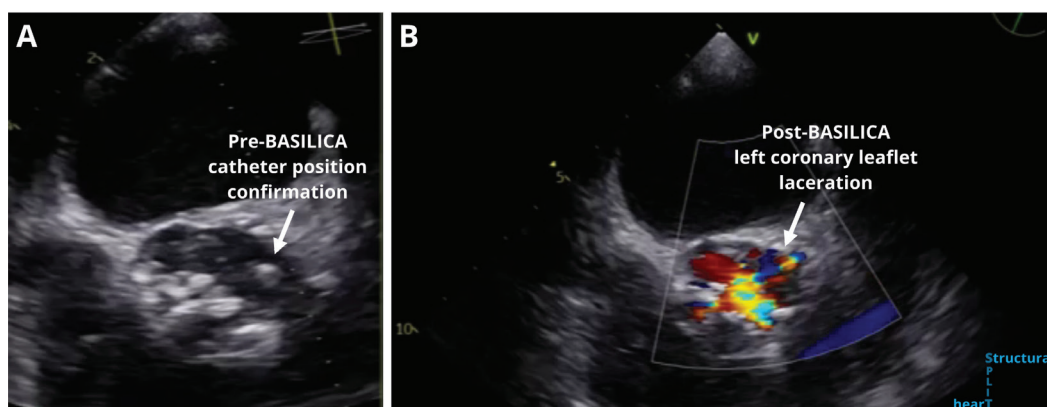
Echocardiographic images: A. Confirmation of catheter position before BASILICA; B. Confirmation of successful left coronary leaflet laceration and splay.
